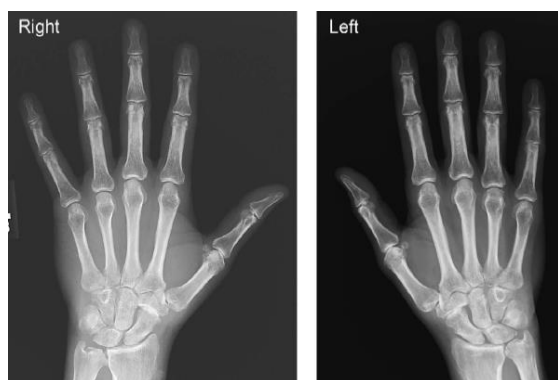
Posterior-anterior (PA) radiographs of the hands bilaterally in the flaring stage of the RS3PE which showing the absence of the bony erosive change unlike rheumatoid arthritis or several seropositive rheumatologic condition.^[7]
